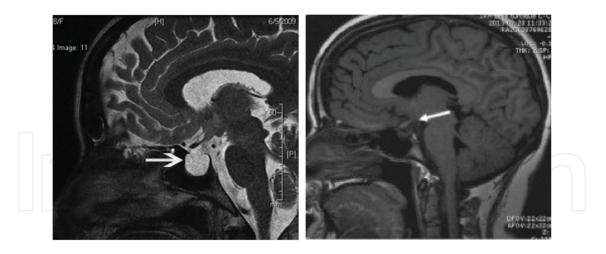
Sagittal T2-weighted image of ESS in an elevated ICP patient [31, 32]. (Left) Pathological findings of "empty sella syndrome" where the arrow points at a completely empty sella. (Right) Anatomically and pathologically healthy individual, for comparison.
